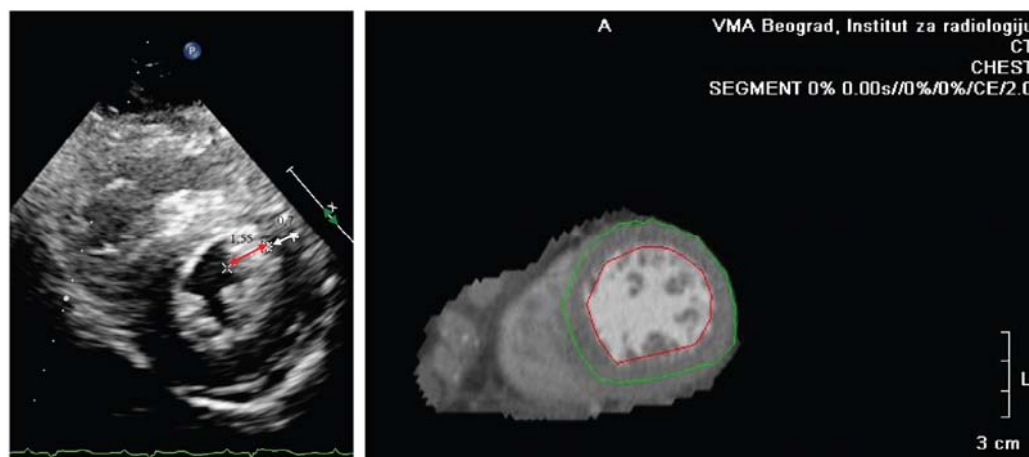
Echocardiography: short-axis view of the left ventricle at end systole, and multislice computed tomography of the heart: the left ventricular myocardium consists of 2 layers – the thick non-compacted layer and the thin compacted layer, their thickness ratio being 2.2:1.
